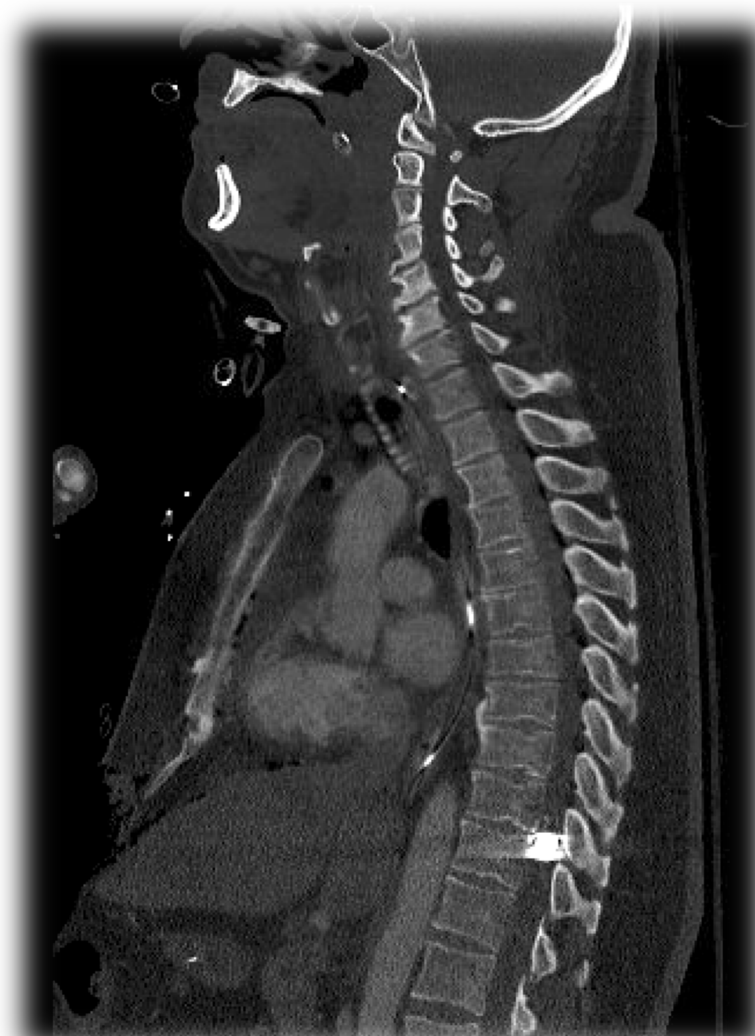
Sagittal Thoracic spine CT imaging demonstrating a retained bullet within the spinal canal at the level T11.
